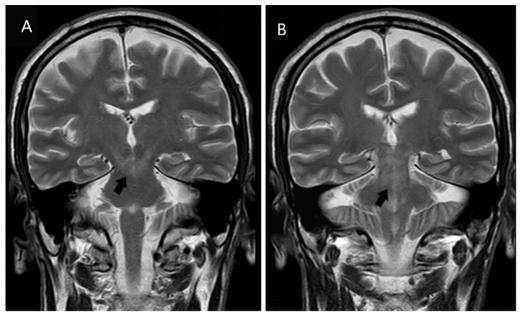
Coronal turbo spin echo T2-weighted magnetic resonance imaging sequences. A Patchy hyperintensity in the midbrain and cerebral peduncles (black arrow). B Hyperintensity involving the central and posterior portion of the pons and medulla oblongata (black arrow)
